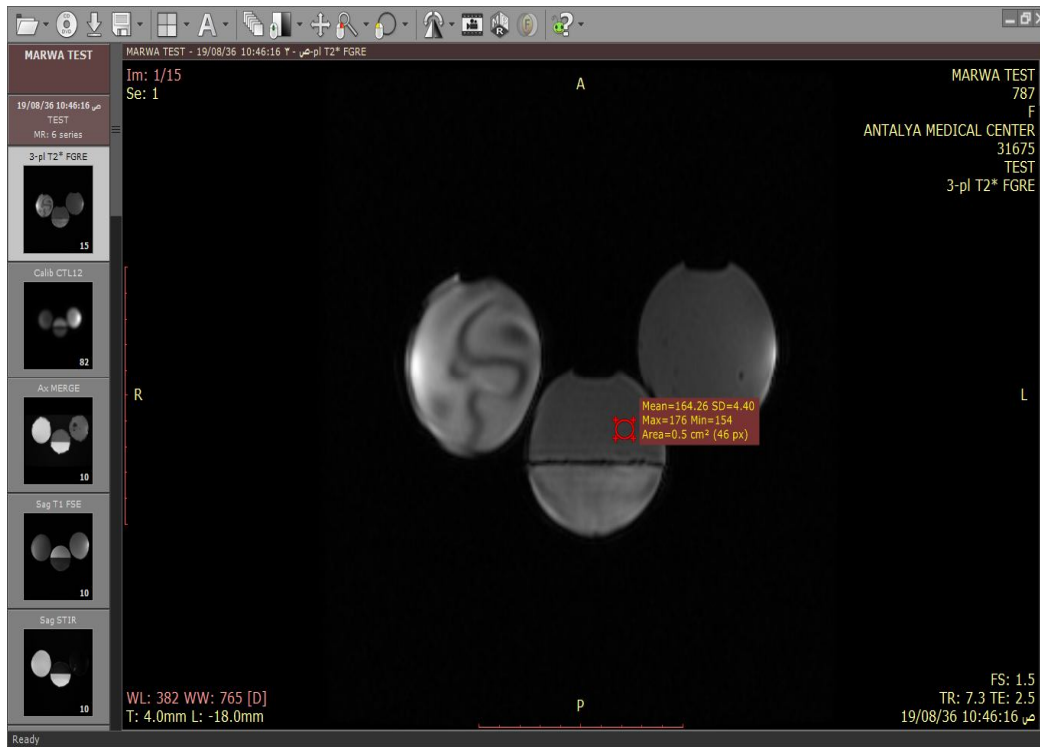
T2 image taken by GE MRI 1.5T in Antalya medical center
